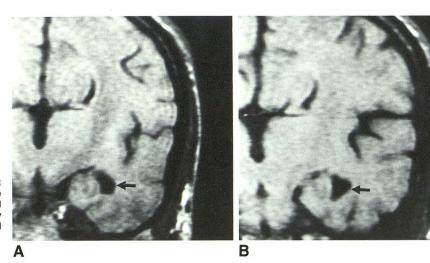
A and B, Coronal T1-weighted MR images of twin 1 (A) and twin 2 (B). Keyhole dilatation of temporal horn (arrow) is caused by hippocampal hypoplasia. Note continuity of interhemispheric fissure with dilated third ventricle.
